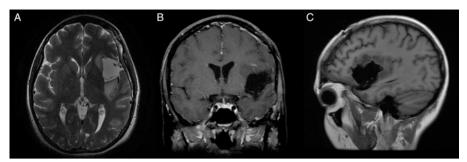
Axial T2-weighted (A), as well as coronal (B) and sagittal (C) T1-weighted magnetic resonance imaging (MRI) obtained 3 months post-operatively, demonstrating a satisfactory subtotal resection of approximately 85% (Pre-operative volume of 97 ml versus Post-operative volume of 15 ml). Residual tumor was disclosed medial to the pars triangularis and to the posteriormost part of the insula.
